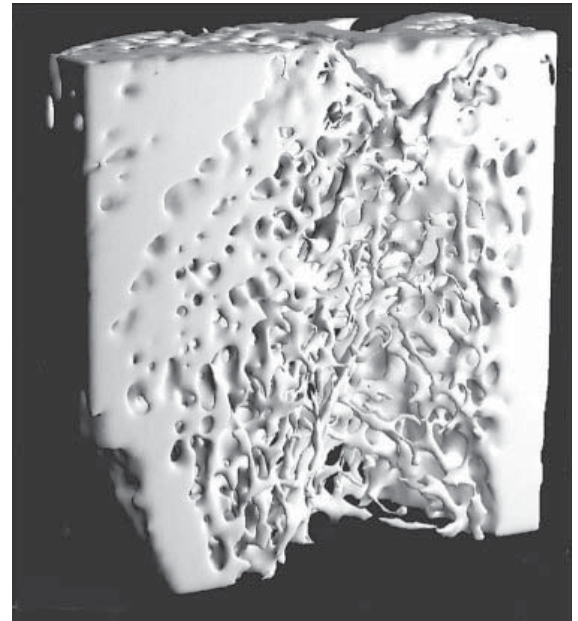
Three-dimensional (3-D) reconstruction of microcomputed tomography (μ CT) slices for a control bone with no tumor and placebo treatment (a 6-mm region is shown)Fig. 2. 3-D reconstruction of μ CT slices for a tumor-bearing bone with placebo treatment (a 6-mm region is shown)
